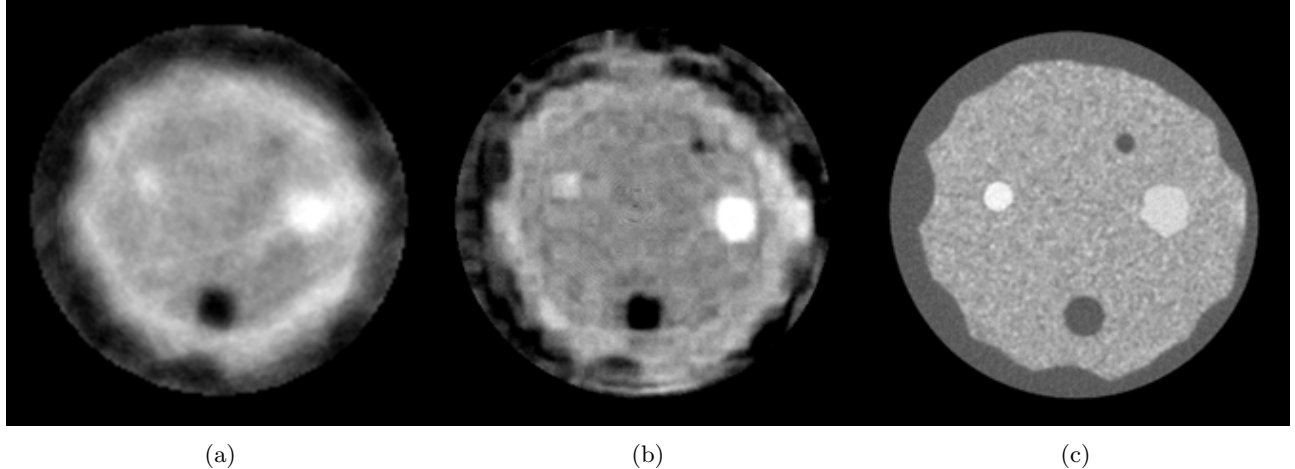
Comparison of morphology between ray based, waveform, and CT reconstruction. Data was acquired by the old prototype. (a) Ray based sound speed; (b) Waveform sound speed; (c) CT.
